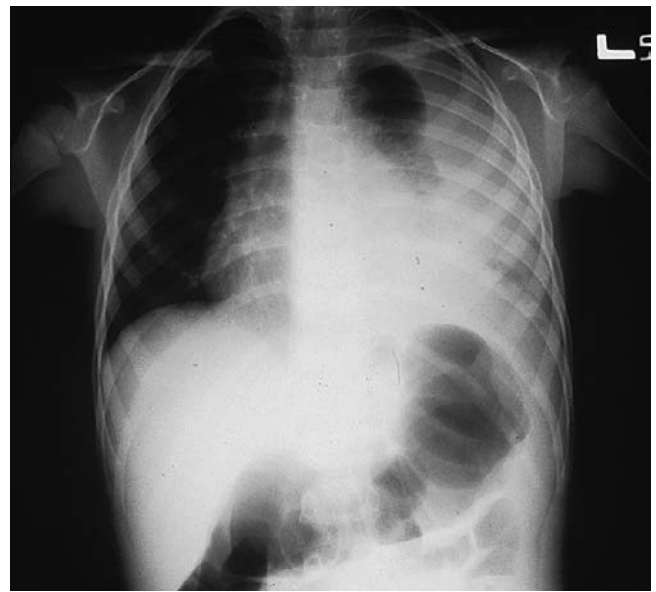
This 5-year-old boy was on a snowmobile when it crashed into a tree. Initially there was no respiratory distress, but upon arrival at the emergency department, the patient became tachypneic and required oxygen. Breath sounds were reportedly normal. Chest radiograph showed a left-sided diaphragmatic hernia. This injury was surgically repaired in the operating room, and the patient did well postoperatively.
